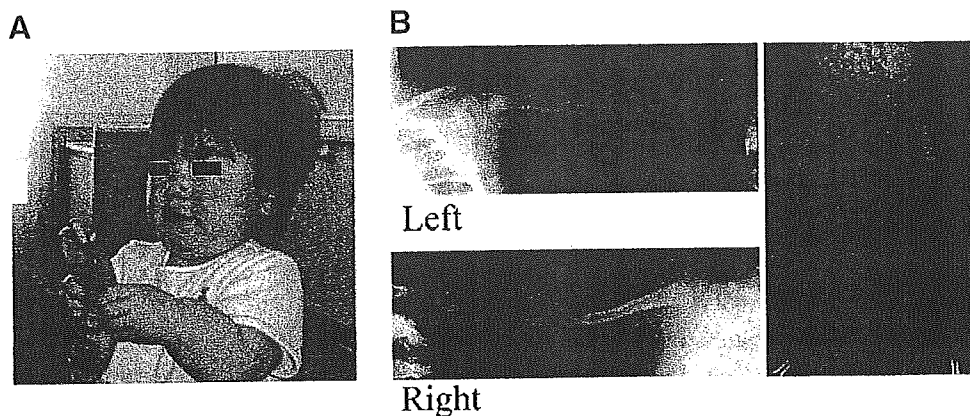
A: Photograph of the infant at 1.5 years of age. B: Roentgenograms of the infant at 7 months of age.
